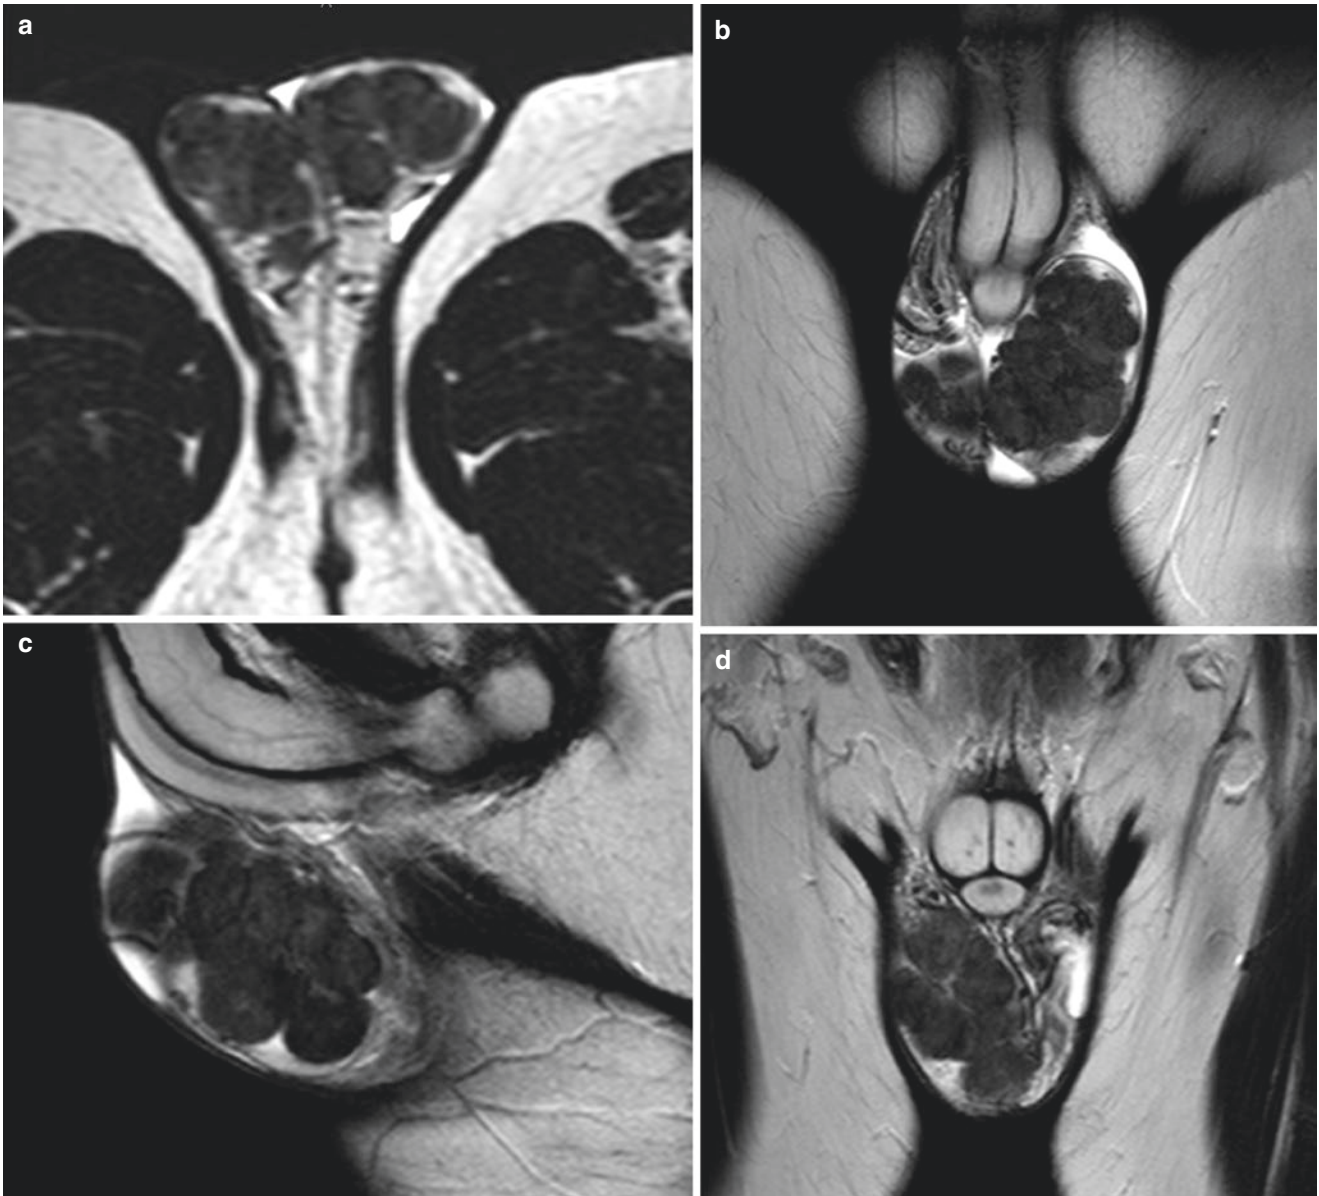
Testicular adrenal rest tumors. T2-weighted MR images of both testicles with lobulated hypointense intratesticular masses occupying the testicular parenchyma (*white arrows*)
